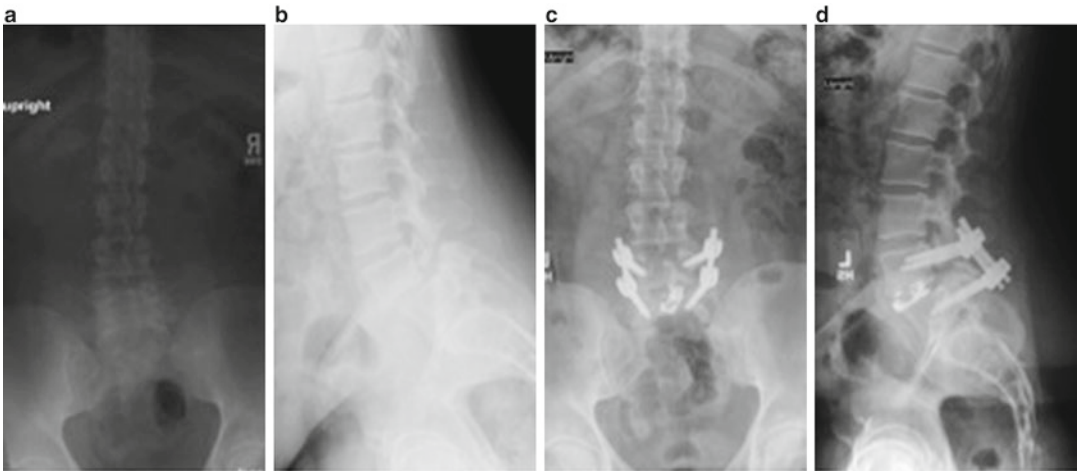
Standing AP and lateral radiographs, preoperative, and postoperative imaging of sacralized L5 vertebra with an isthmic spondylolisthesis at L5-S1 treated with MIS TLIF and an expandable cage
